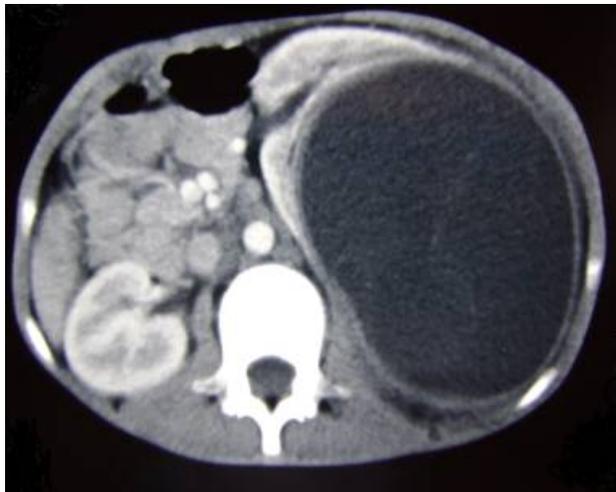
Abdominal computed tomography shows, large cyst compresses left kidney parenchyma and pushes kidney to the midline.
